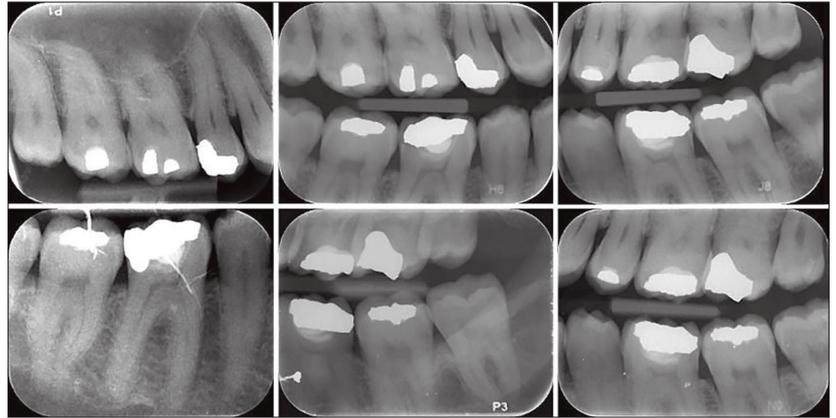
Intraoral radiographs revealing no evidence of dental sepsis and restorative fillings of the teeth.
